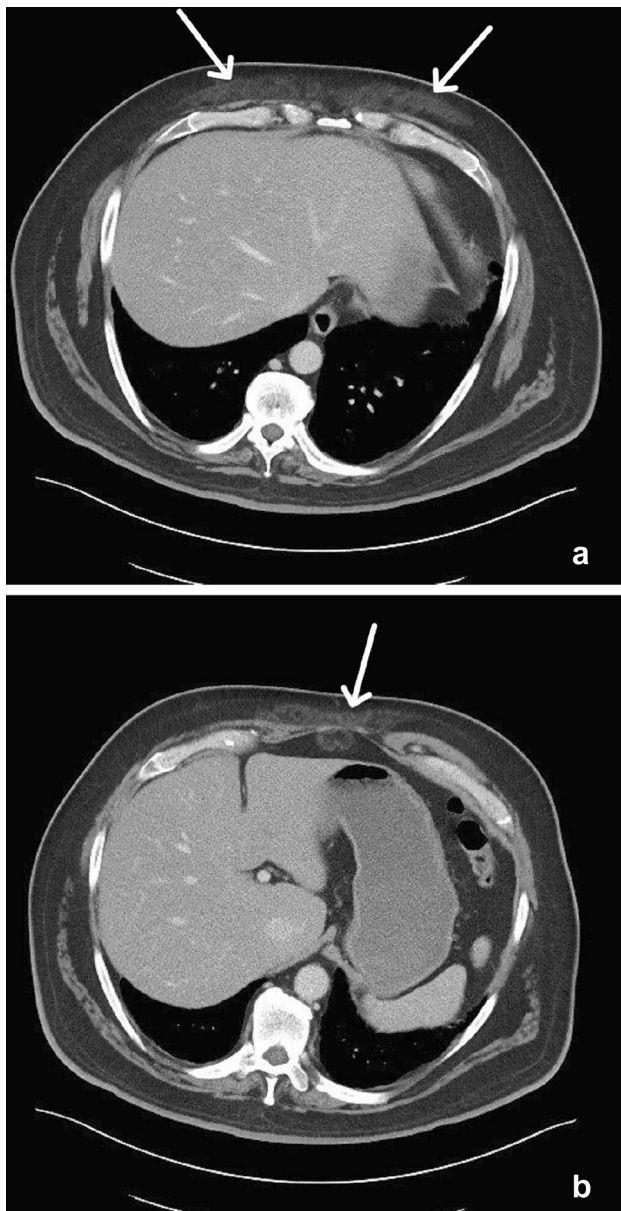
52-year-old male with subcutaneous panniculitis. Two axial (a, b) CT images through the upper abdomen demonstrate increased attenuation and inflammatory changes in the anterior abdominal wall subcutaneous fat (arrows), consistent with subcutaneous panniculitis
